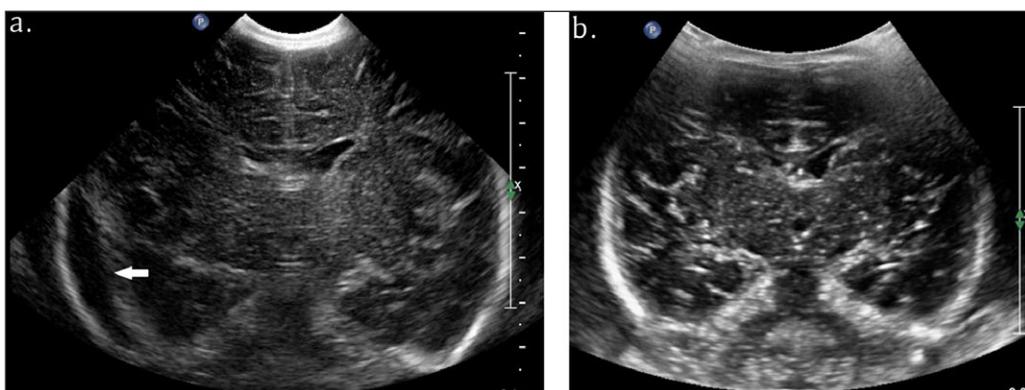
Ultrasound of a 4-day-old with perinatal asphyxia. a. US with micro-convex C8-5 MHz probe: mirror-image artifact of extra-cranial fluid creating the image of subdural hematoma in the right temporal region (arrow). b. Repeat US with convex C5-1 MHz probe demonstrates absence of subdural hematoma.
